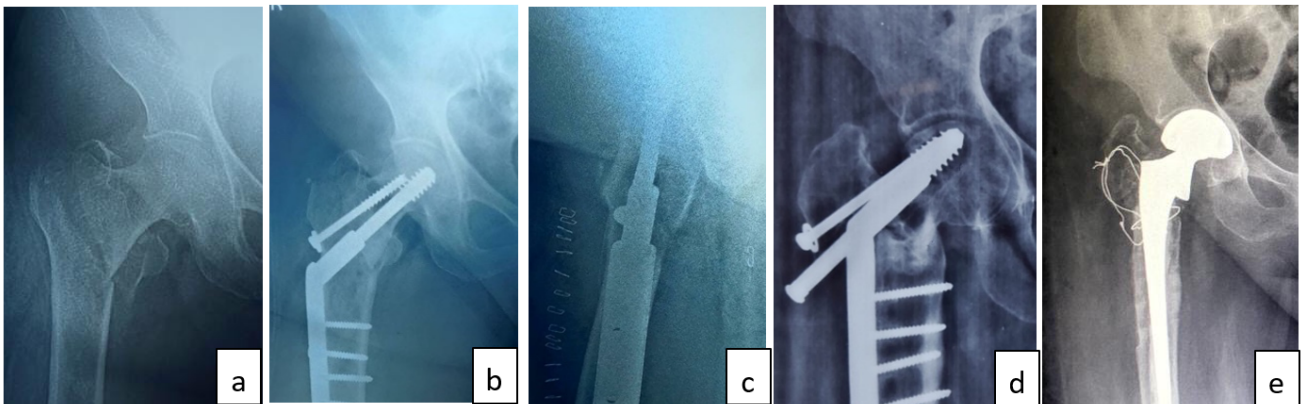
Failed fixation case 1. Immediate post-operative radiographs of AO type 31A2.1 fracture show a total stability score of 6 (b&c). Fixation failed to achieve union with 6 months follow up X-ray showing varus collapse with screw back-out (d), subsequently revised to hemiarthroplasty
